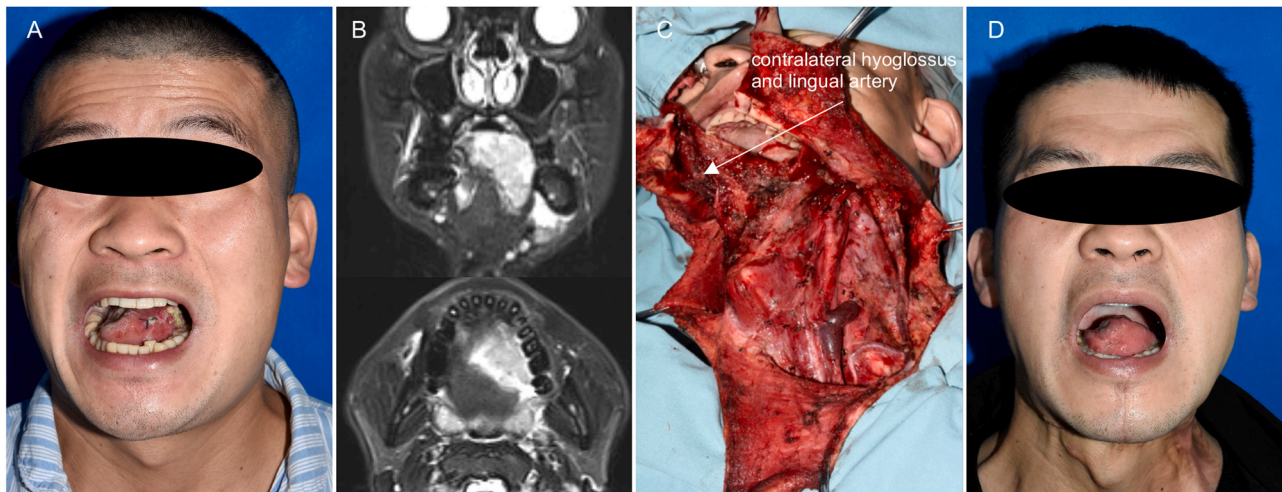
Invasion of the contralateral MGC by the primary tumour. (A) Preoperative photograph. (B) MRI of the primary tumour. (C) The contralateral hyoglossus and lingual artery were preserved after resection of the contralateral MGC. (D) Appearance at 18 months after surgical treatment. (MGC, musculus verticalis linguae–genioglossus complex.).
